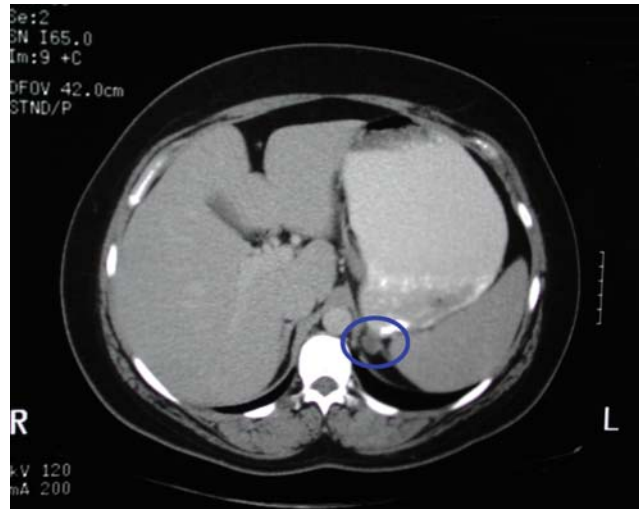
A CT scan with thin cuts through the adrenal glands shows an aldosterone-producing adenoma on the left.
